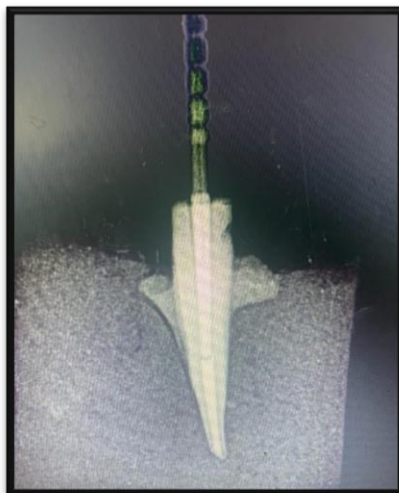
POST CEMENTATION PERIAPICAL RADIOGRAPH WAS RECORDED FOR VERIFICATION OF THE POST FIT.
